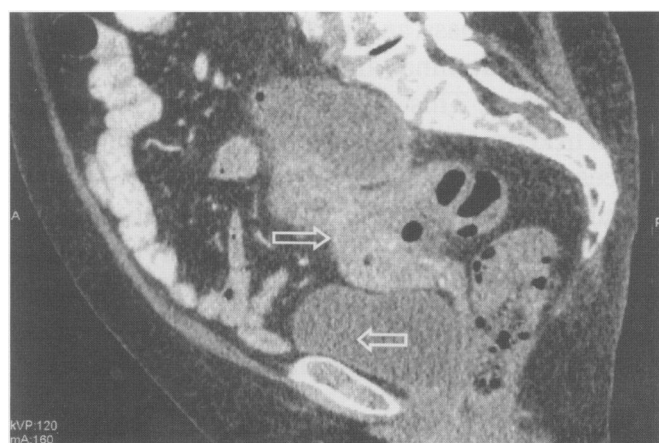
Multidetector computed tomography reconstructed in sagittal plane showing fundus of uterus communicating with abscess cavity and thickened diseased sigmoid colon (right facing arrow). The left facing arrow denotes the bladder.
